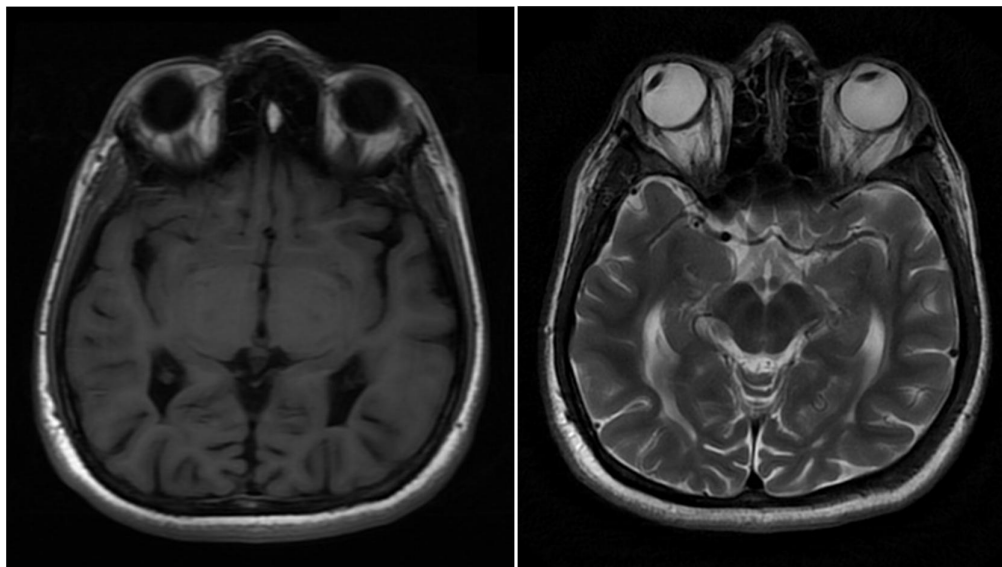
MRI Brain T1 & T2 Axial showing Periventricular Leucomalacia (Undulating ventricular margin)
